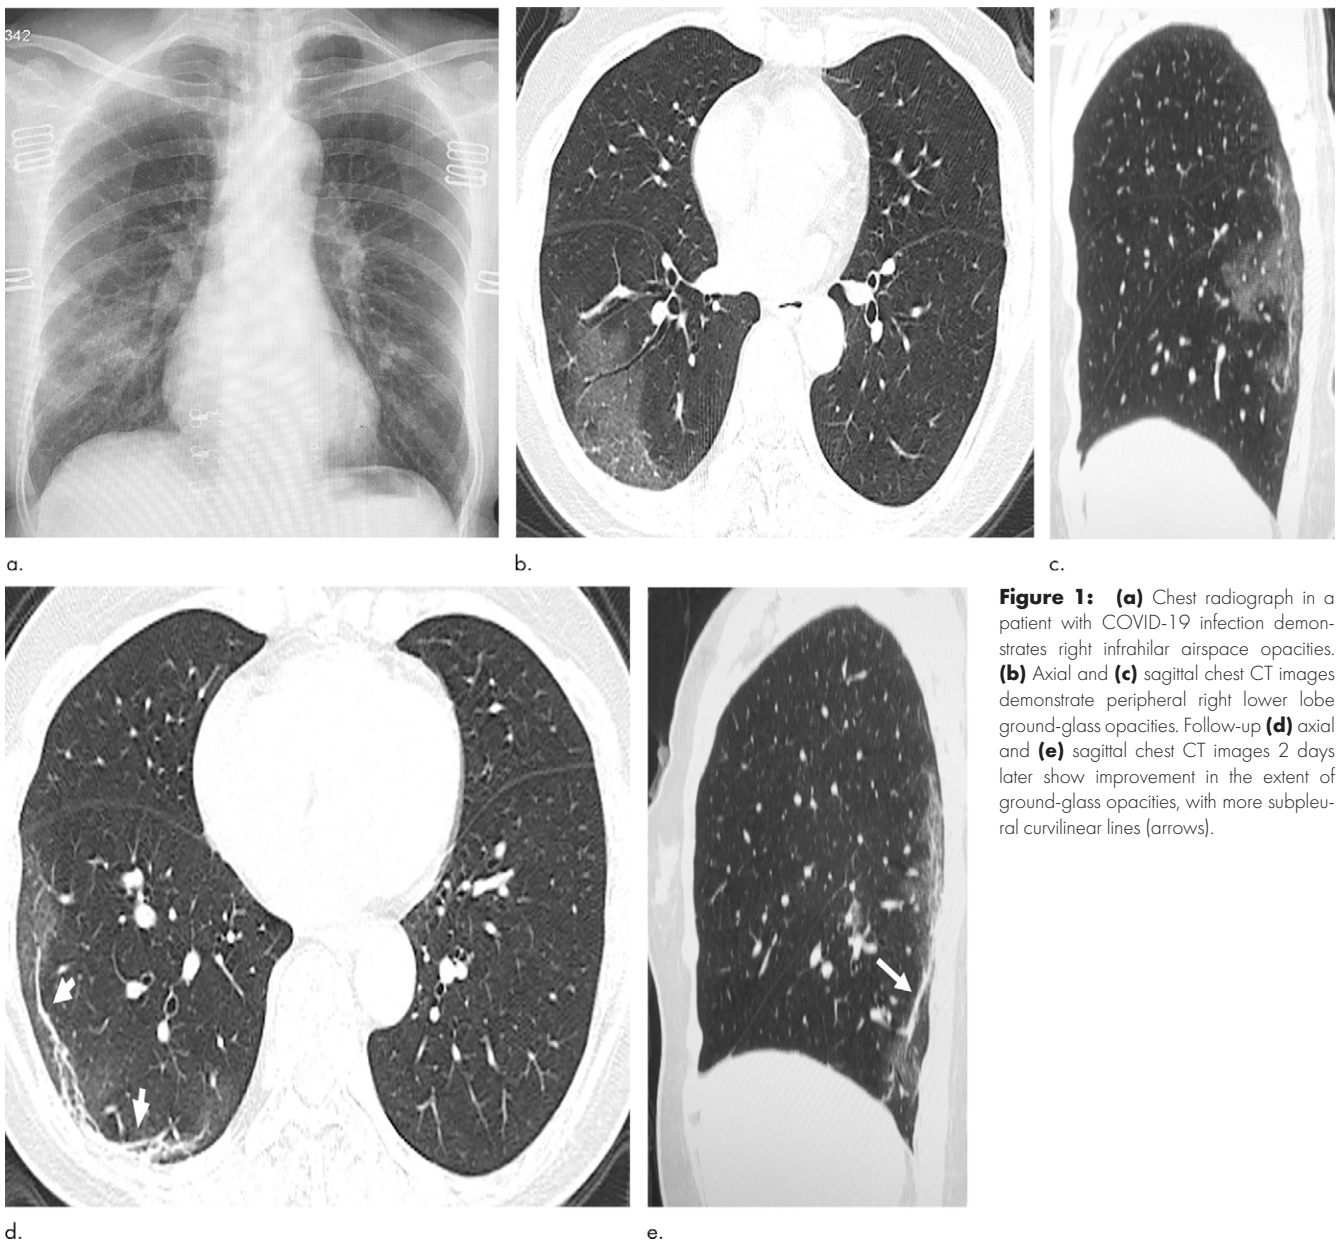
(a) Chest radiograph in a patient with COVID-19 infection demonstrates right infrahilar airspace opacities. (b) Axial and (c) sagittal chest CT images demonstrate peripheral right lower lobe ground-glass opacities. Follow-up (d) axial and (e) sagittal chest CT images 2 days later show improvement in the extent of ground-glass opacities, with more subpleural curvilinear lines (arrows).
